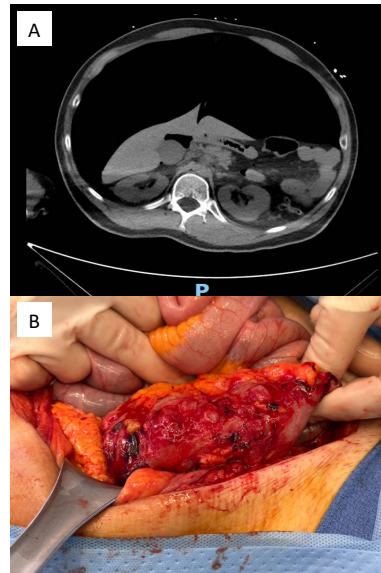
Extensive pneumoperitoneum 9 x 10 x 5 cm circumferentially on axial computed tomography
